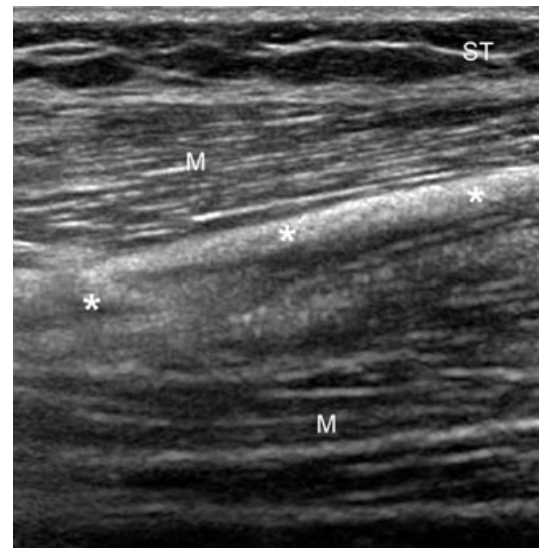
Polymethylmethacrylate (PMMA) within the ischiotibial muscles. Ultrasound (longitudinal view) shows hyperechoic bright dots (*Mini comet-tail shaped artefact) within the ischiotibial muscles. ST, subcutaneous tissue; M, ischiotibial muscles.
